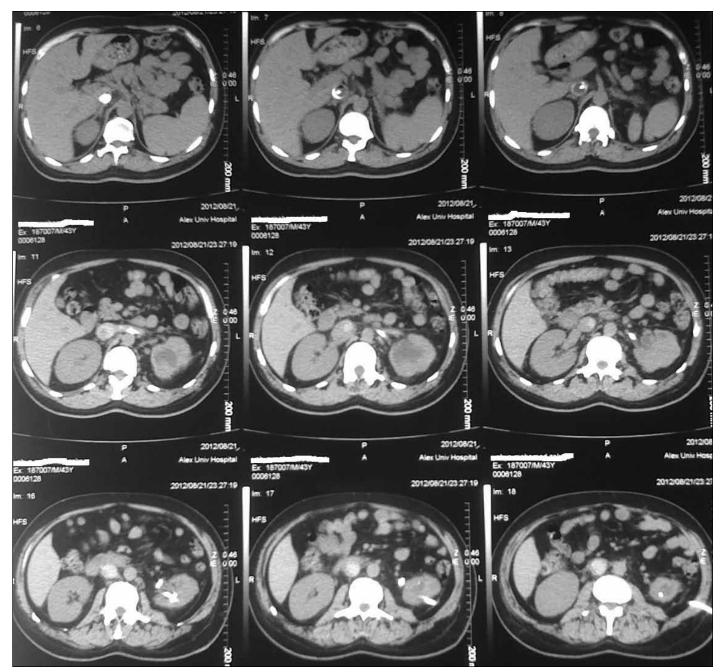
The computed tomography showing the silicon catheter traversing the renal parenchyma, passing through the left renal vein and ending, with the balloon inflated, in the inferior vena cava.
